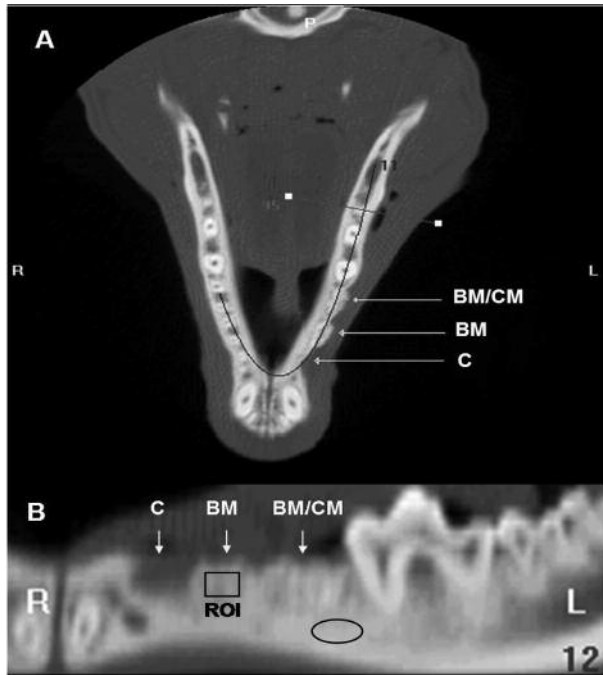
View of the display of the software program showed defective extraction sites (arrows) filled by grafted mineral particles on the CT slice at 8 weeks post-operation. A, One of the transverse images was selected as the reference transverse slice image. One arch to the center plane was drawn, and this was taken as a reference point when carrying out the series of panoramic images. B, A "panoramic projection" image was reconstructed from serial panoramic images. The average pixel densities of a 5 mm² ROI area (indicated as a square) centered over the crestal areas of all extraction socket defects on the panoramic projection image was divided by that of the intact adjacent alveolar bone (indicated as circle) and expressed as a percentage.
